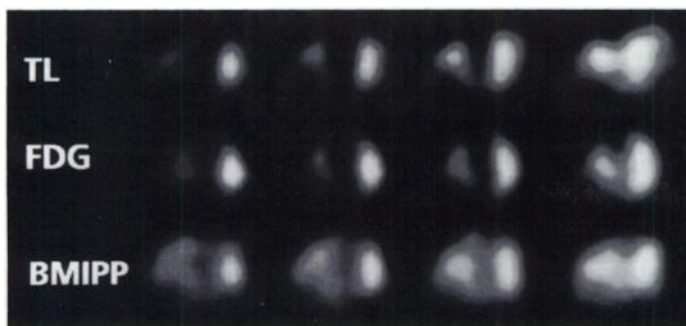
Female patient with a 6-yr-old anteroseptal infarction. The horizontal long-axis shows a FDG/Tl match but a BMIPP/Tl mismatch in the septal wall.
